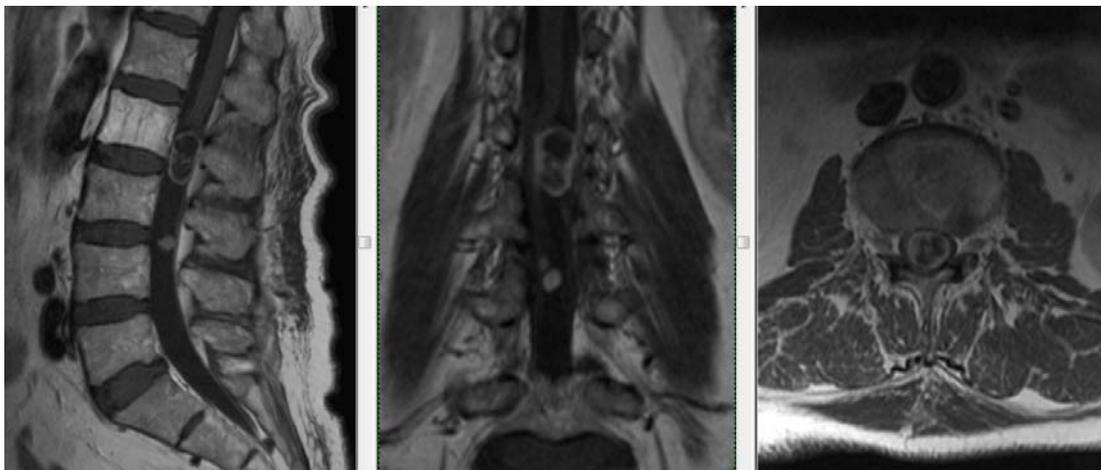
T1-weighted (sagittal, coronal and axial) gadolinium-enhanced MRI images (2011) in which the 3 schwannomas of the cauda equina can be noticed
